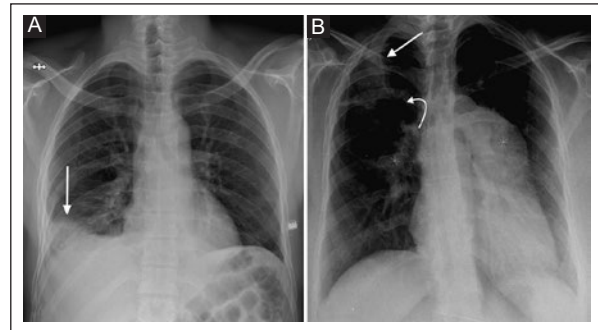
A: a 42-year-old female patient with a diagnosis of pulmonary embolism. Chest X-ray, posteroanterior view. A wedge-shaped opacity is observed with an apex towards the pulmonary hilum in the right basal location corresponding to Hampton’s hump with slight volume loss of the right lower lobe and obliteration of the costophrenic angle on this side (arrow). B: 56-year-old female patient with a diagnosis of pulmonary embolism. Chest X-ray, posteroanterior projection. A wedge-shaped opacity is observed with apex towards the pulmonary hilum located in the right upper lobe corresponding to Hampton’s hump (arrow). Likewise, there is prominence of the pulmonary arteries representing the Fleischner sign (asterisk) and some areas of lower density or radiolucency of the parenchyma around the opacity and in the upper right lobe that may correspond to areas of oligemia representing the Westermark sign (curved arrow).
